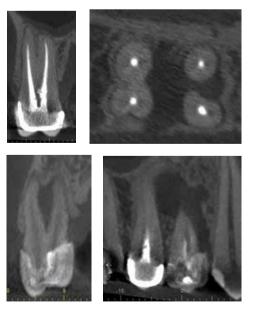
and 1C: The sagittal reconstructed CBCT section with removal of the overlying anatomy (B) and coronal section through the mesial root of the UR7 (C) clearly show a periapical area associated with this root due to a poorly filled mesial canal and unfilled separate MB2. Due to the lack of signs and symptoms from the UR6, it was decided that the bone loss around the distal root was likely to be from pus discharge from the UR7. The patient elected to have the UR7 extracted, and the abscess resolved immediately
